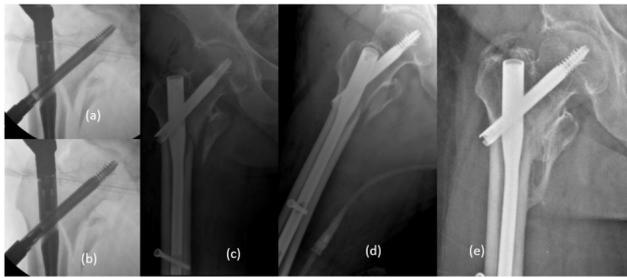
(a,b) Intraoperative fluoroscopy of claw deployment and fracture compression. Anterior-posterior (c) and lateral (d) postoperative radiographs of the Zimed proximal femoral nail with interclaw lag screw. (e) The complete union was observed at three months in clinical follow-ups.
